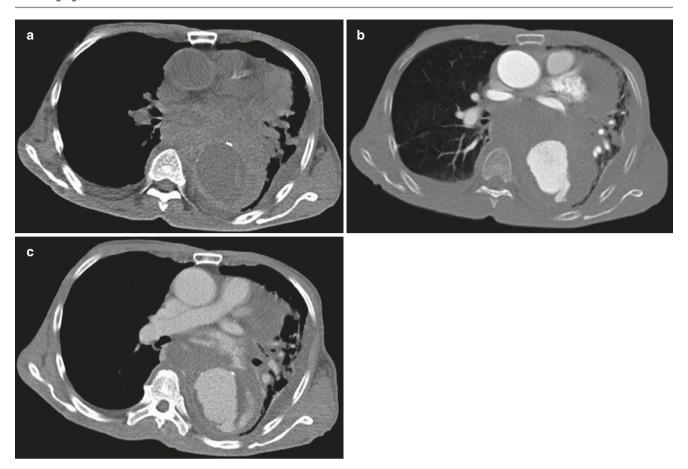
Rupture of descending thoracic aortic aneurysm with active bleeding. (a) Axial unenhanced, (b) arterial phase and (c) delayed phase CT. Note the aortic lumen shows low attenuation compared to extravascular hematoma
